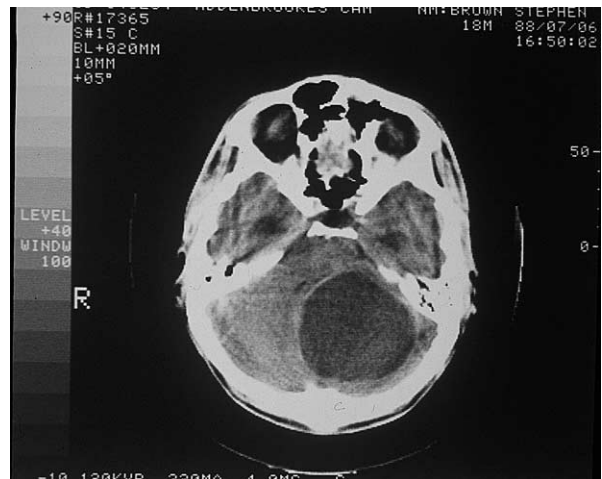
This computed tomography head scan shows a large cystic lesion in the right cerebellar hemisphere. It is producing a mass effect and is displacing the brainstem and cerebral aqueduct. The patient presented in a coma and at operation was found to have a hemangioblastoma, which was resected with good result.
